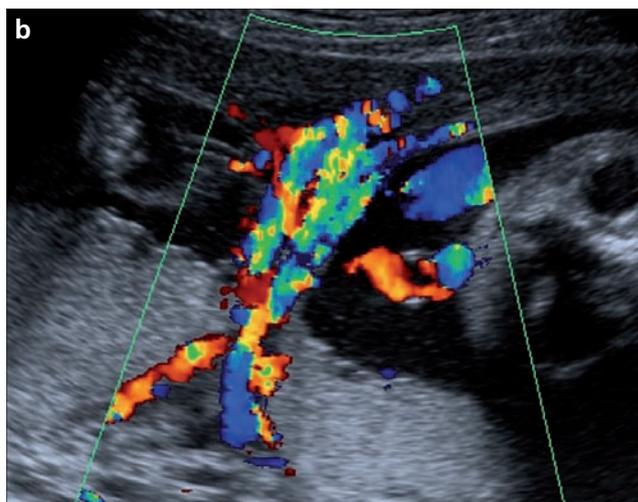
a, b. A sagittal US view (a) of the patient no. 2 showing a relatively thick amniotic sheet (arrows) with placental extension. A color Doppler US view (b) shows substantial arterial vascularization. Spectral analysis is not shown.
